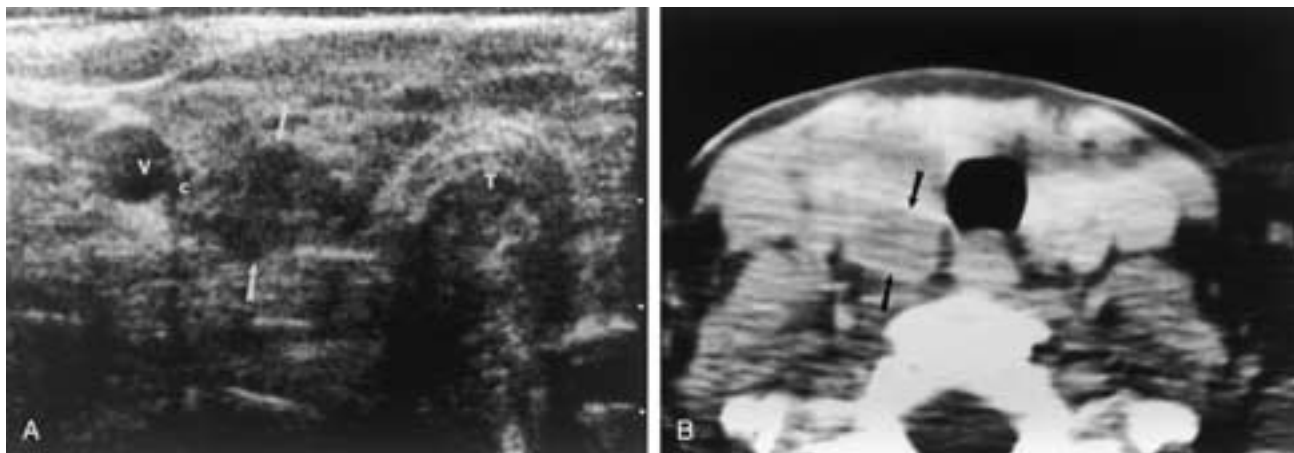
Hashimoto's thyroiditis. A, Transverse ultrasound image showing heterogeneity in the echotexture of the right lobe of the thyroid gland with a more focal region of decreased echogenicity posteriorly (arrows). *V*, Jugular vein; *C*, carotid; *T*, trachea. B, Corresponding enhanced axial CT scan shows a focal region of hypodensity (arrows) corresponding to the abnormality seen on ultrasound.
